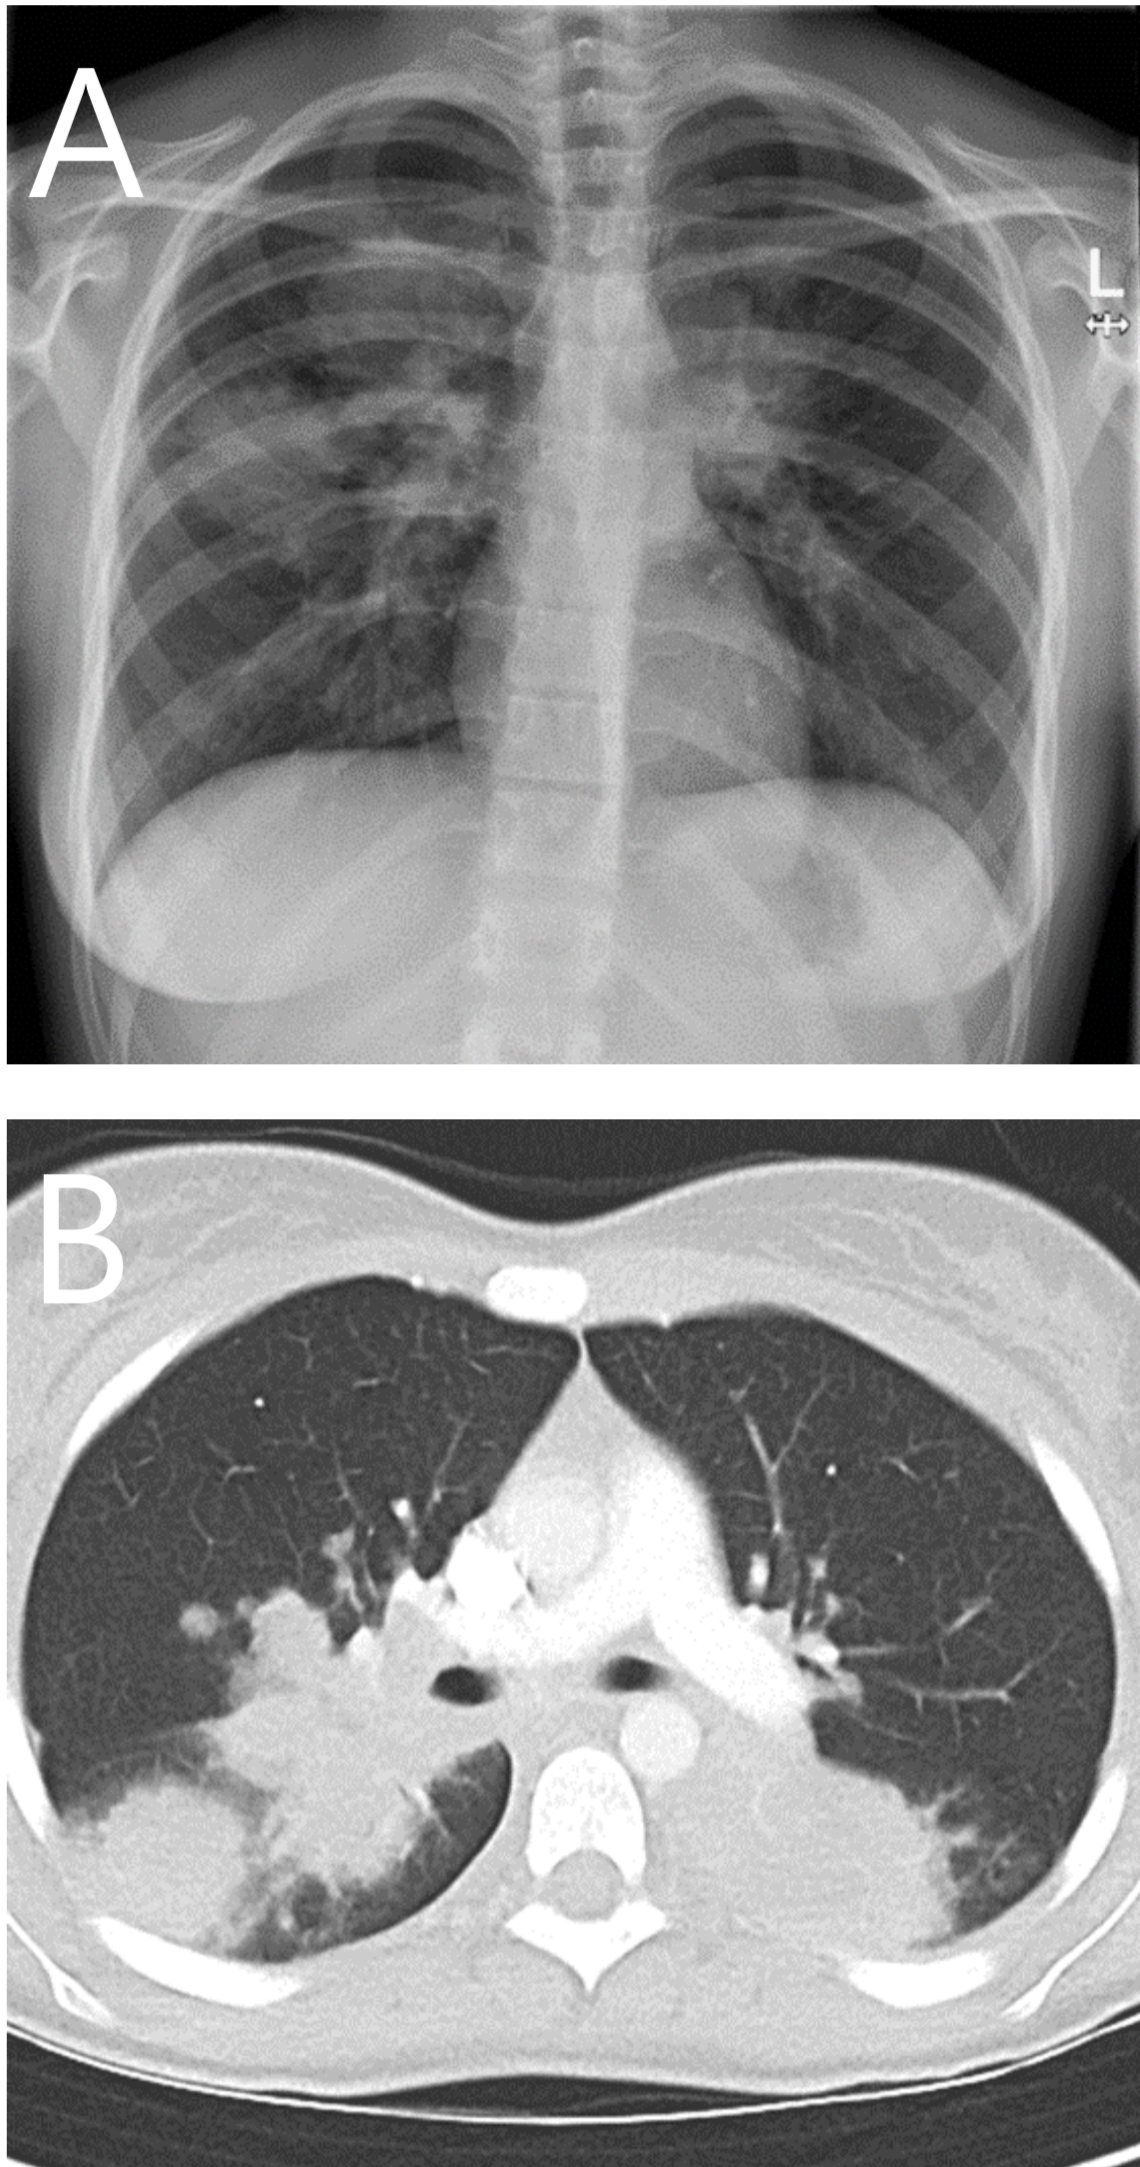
Chest X-ray (A): infiltrates and lymphadenopathy; Lung CT scan (B): multi-local consolidations
